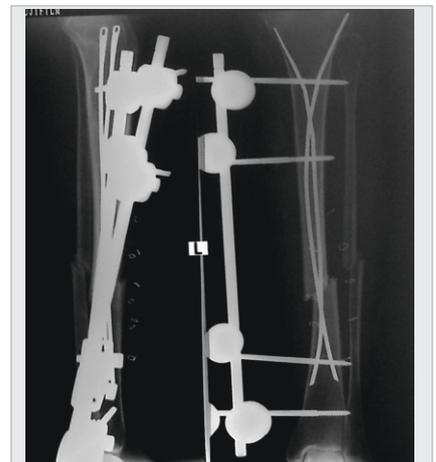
case2 Preop Xray 55 yr female with road accident, open type2 fracture middle 3rd tibia/Fibula
